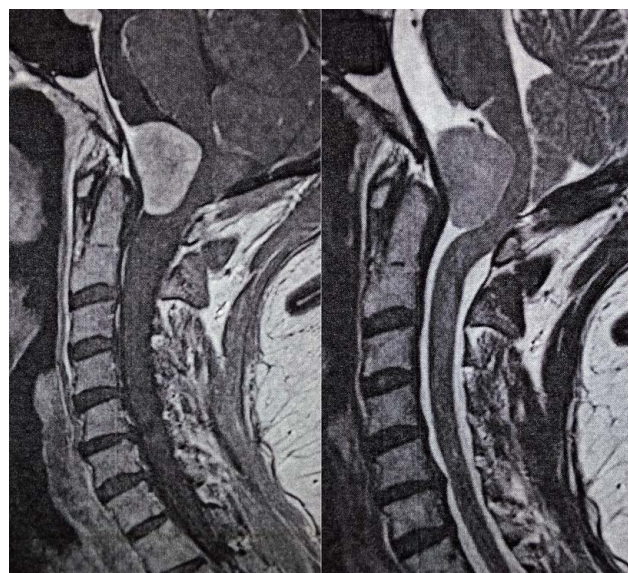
Preoperative sagittal contrast-enhanced T1WI and T2WI MRI scan
